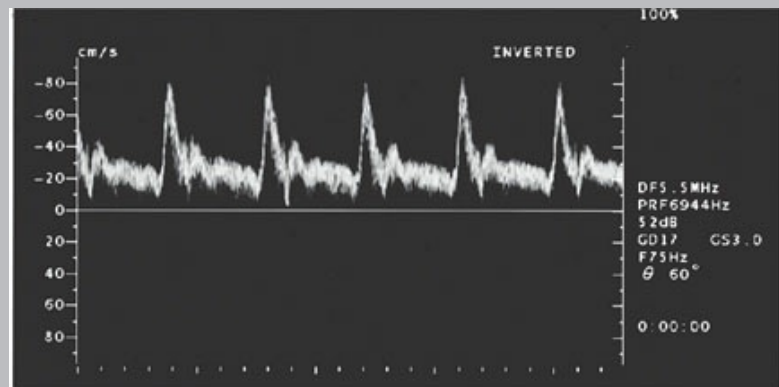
Pulsed Doppler Aliasing. A. Pulsed waveform of internal carotid shows normal systolic peaks. B. Sampling rate set too low demonstrating aliasing. C. Further decrease in sampling rate produces more aliasing.
